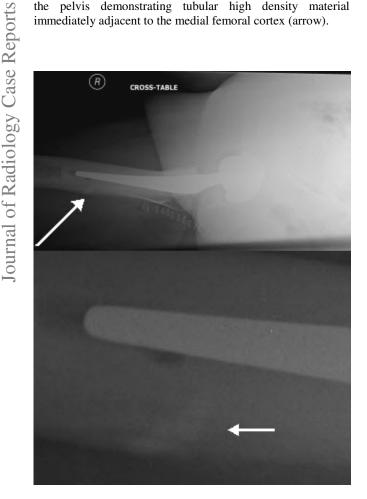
63 year old female with PMMA extrusion into the femoral nutrient vessel during arthroplasty. Lateral radiograph with arrow highlighting high density region.
